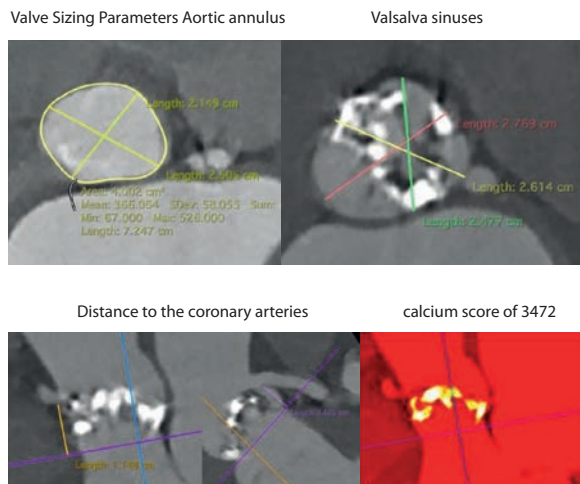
Pre-TAVI CT assessment of bicuspid aortic valve: measurement of the aortic annulus, Valsalva sinuses, distance to the coronary arteries, and calcium burden.
